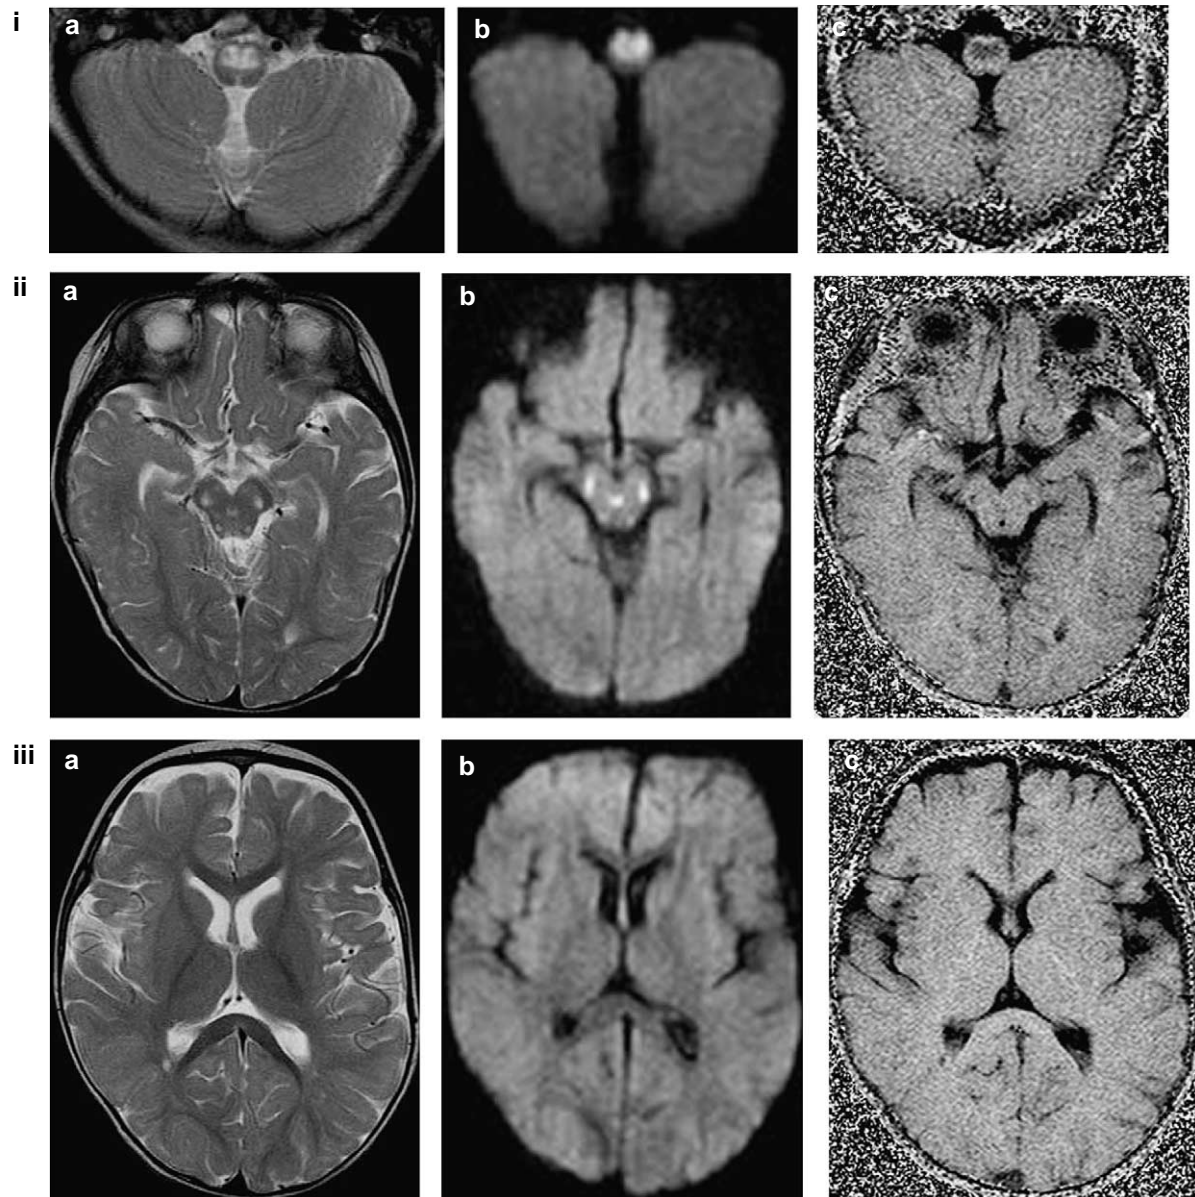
A 10-month-old boy with Leigh's disease and global developmental delay. (ia) Axial T2-weighted image shows hyperintensity in the medulla-cervical cord anteriorly suggesting dysmyelination. The lesions are hypointense on T1-weighted image (not shown). (ib) Diffusion-weighted image and (ic) MTR map demonstrates MTR as low signal intensity in the corresponding white matter tracts (iia) T2-weighted image at midbrain level in the same child shows symmetrical dysmyelination in bilateral substantia nigra laterally, colliculi, and periaqueductal gray matter. Low ADC and low MTR are demonstrated as high and low signal intensities on the (iib) diffusion-weighted image and (iic) MTR map, respectively. The occipital periventricular white matter lesions in the same patient are more chronic with (iiia) T2 prolongation, (iiib) normal diffusion, and (iiic) slightly low MTR.
